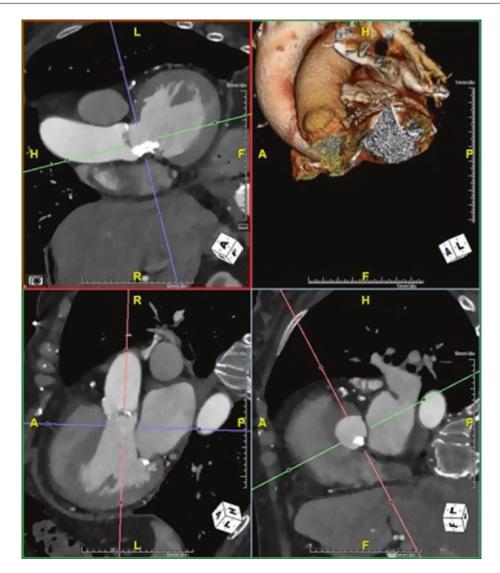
Cardiac CT angiography showing severe nodular aortic annular calcification extending into the left ventricle
